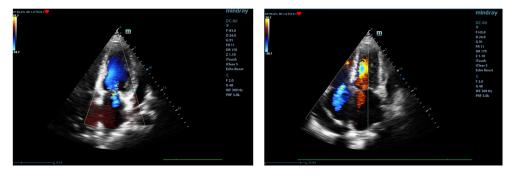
c.6. Mild mitral and tricuspid regurgitation associated in the case presented (color Doppler, apical 4-chambers view)
